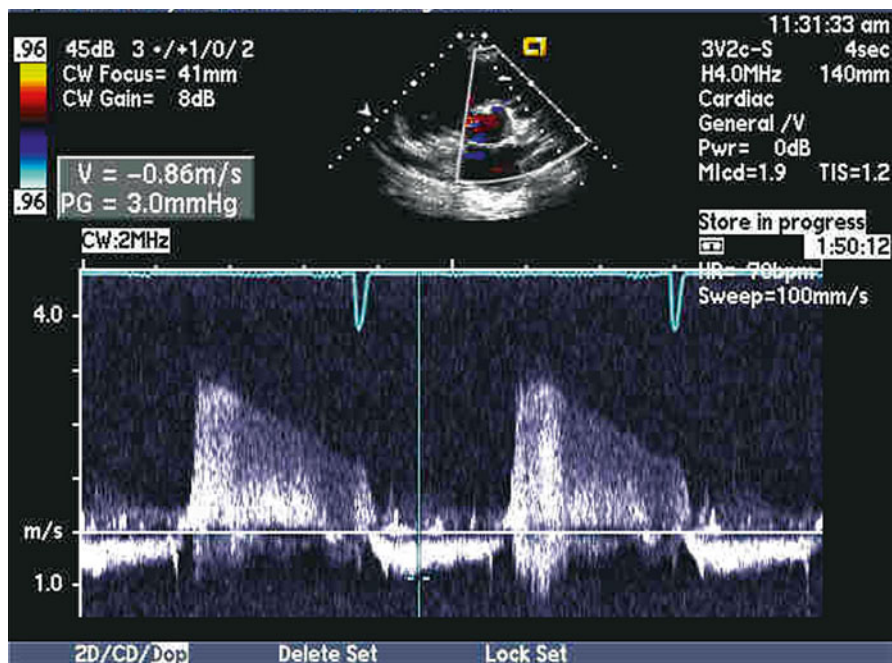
Doppler echocardiogram showing the diastolic velocity profile of pulmonic regurgitation. This has the same general features of aortic regurgitation, however typically at lower velocities due to the lower pressure in the pulmonary artery. For example, not the peak velocity is approximately 3 m/s. The decreasing velocity profile is consistent with the decrescendo nature of the associated murmur
